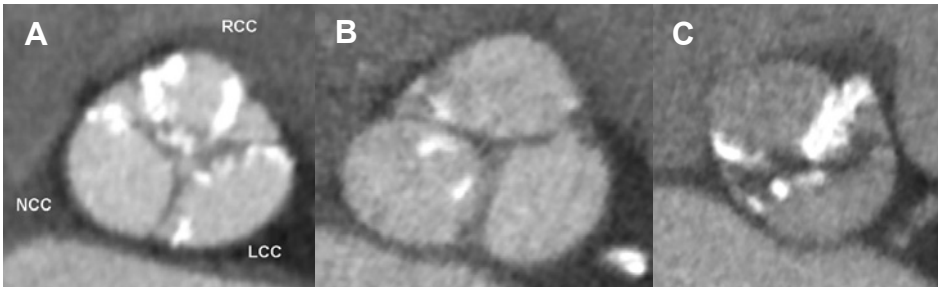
CTA assessment of aortic valve anatomy and morphology. Variations in morphology and anatomy can be identified using CTA. Heavily calcified tricuspid valve (A). Tricuspid valve with minor calcifications (B). Heavily calcified bicuspid valve (C).
